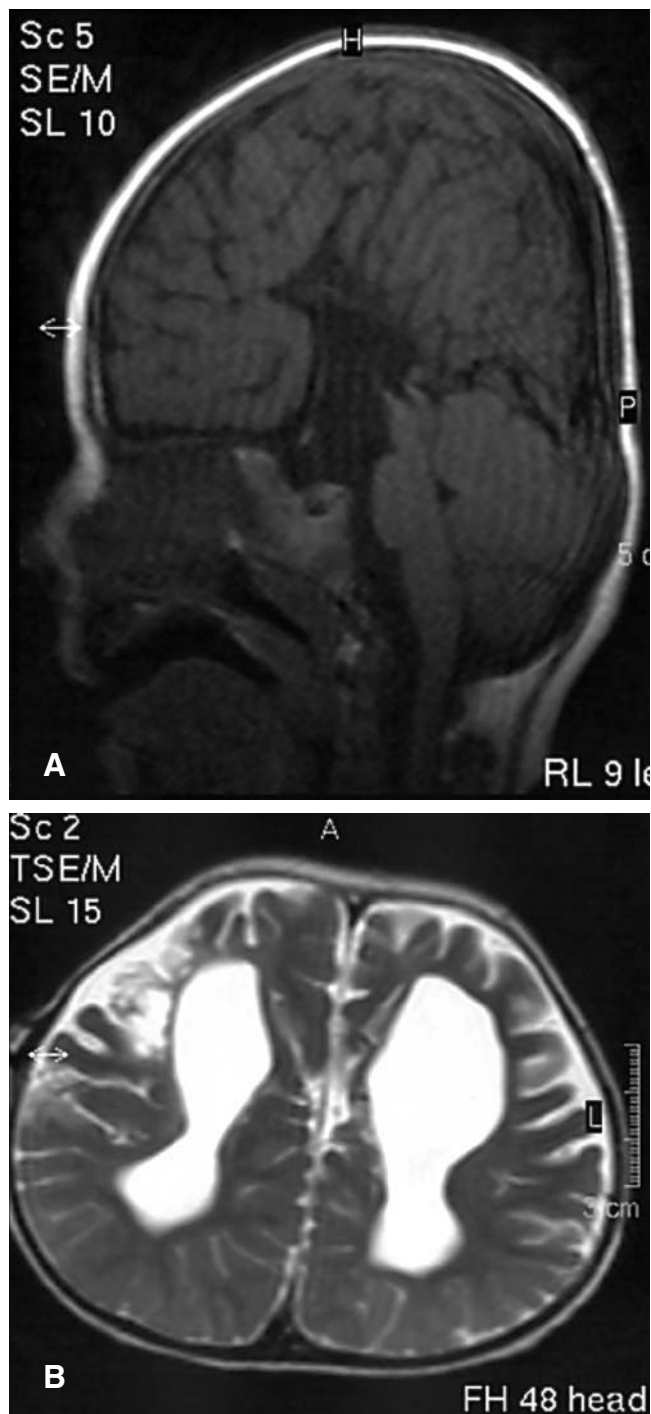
Magnetic resonance images (MRIs) of the head of a 4-year-old boy with complete callosal agenesis with Hallermann-Streiff syndrome. *A*, Sagittal  $T_1$ -weighted MRI shows brachycephaly with parietal bossing and complete agenesis of the corpus callosum with radial or spoke-wheel arrangement of the gyri along the interhemispheric fissure and a high-riding third ventricle. *B*, Axial  $T_2$ -weighted MRI demonstrates dilated, widely spaced, parallel lateral ventricles with encephalomalacic change near the right lateral ventricle. Note the pump of the ventriculoperitoneal shunt in the subcutaneous tissue on the right side. *C*, Coronal  $T_2$ -weighted MRI reveals dilatation in the third and lateral ventricles. A hyperintense encephalomalacic area appears near the right ventricle. Note the high-riding third ventricle in continuity with the interhemispheric fissure.
